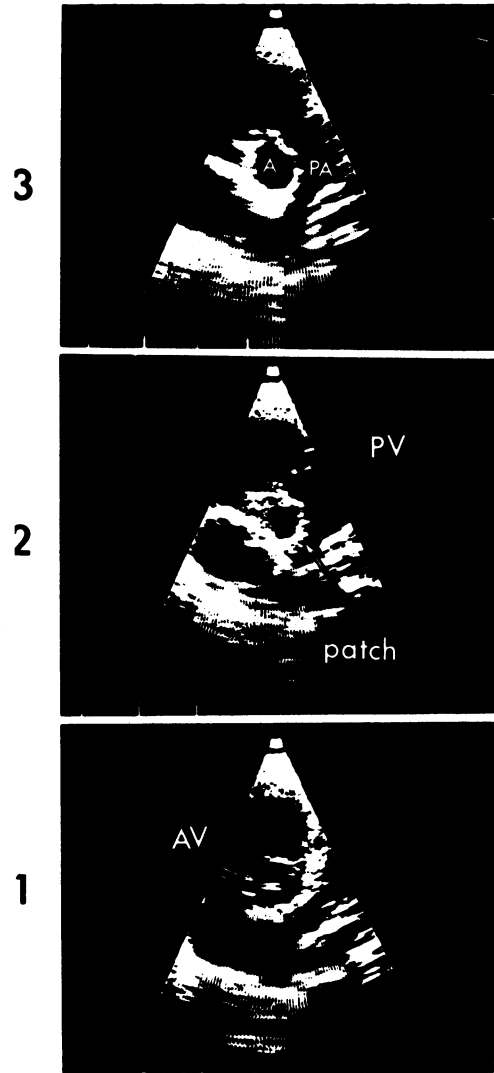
Postoperative two-dimensional echocardiographic findings in case 2. AV, aortic valve; PV, pulmonary valve; Ao, aorta; PA, pulmonary artery; patch, patch echo.
